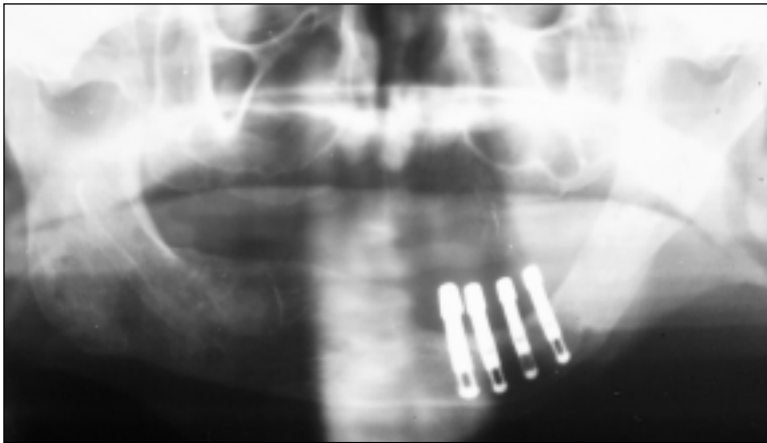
Orthopantomogram. To avoid implant placement into the original, irradiated (40 Gy) right mandible, 4 IMZ implants (Friatec, Mannheim, Germany) were unfavorably, unilaterally placed in a mandible reconstructed by an iliac bone graft.
